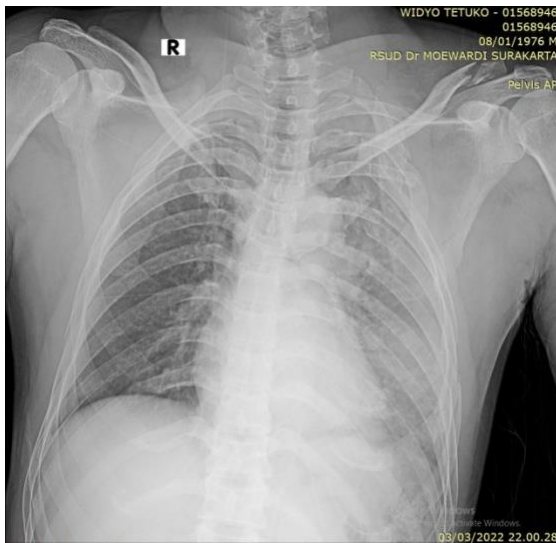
X-ray of the thorax show multiple rib fractures and haemothorax on the left lung. Evaluation by the thoracic and cardiovascular surgery team identified left pulmonary contusion, left hemothorax, and multiple rib fractures.
